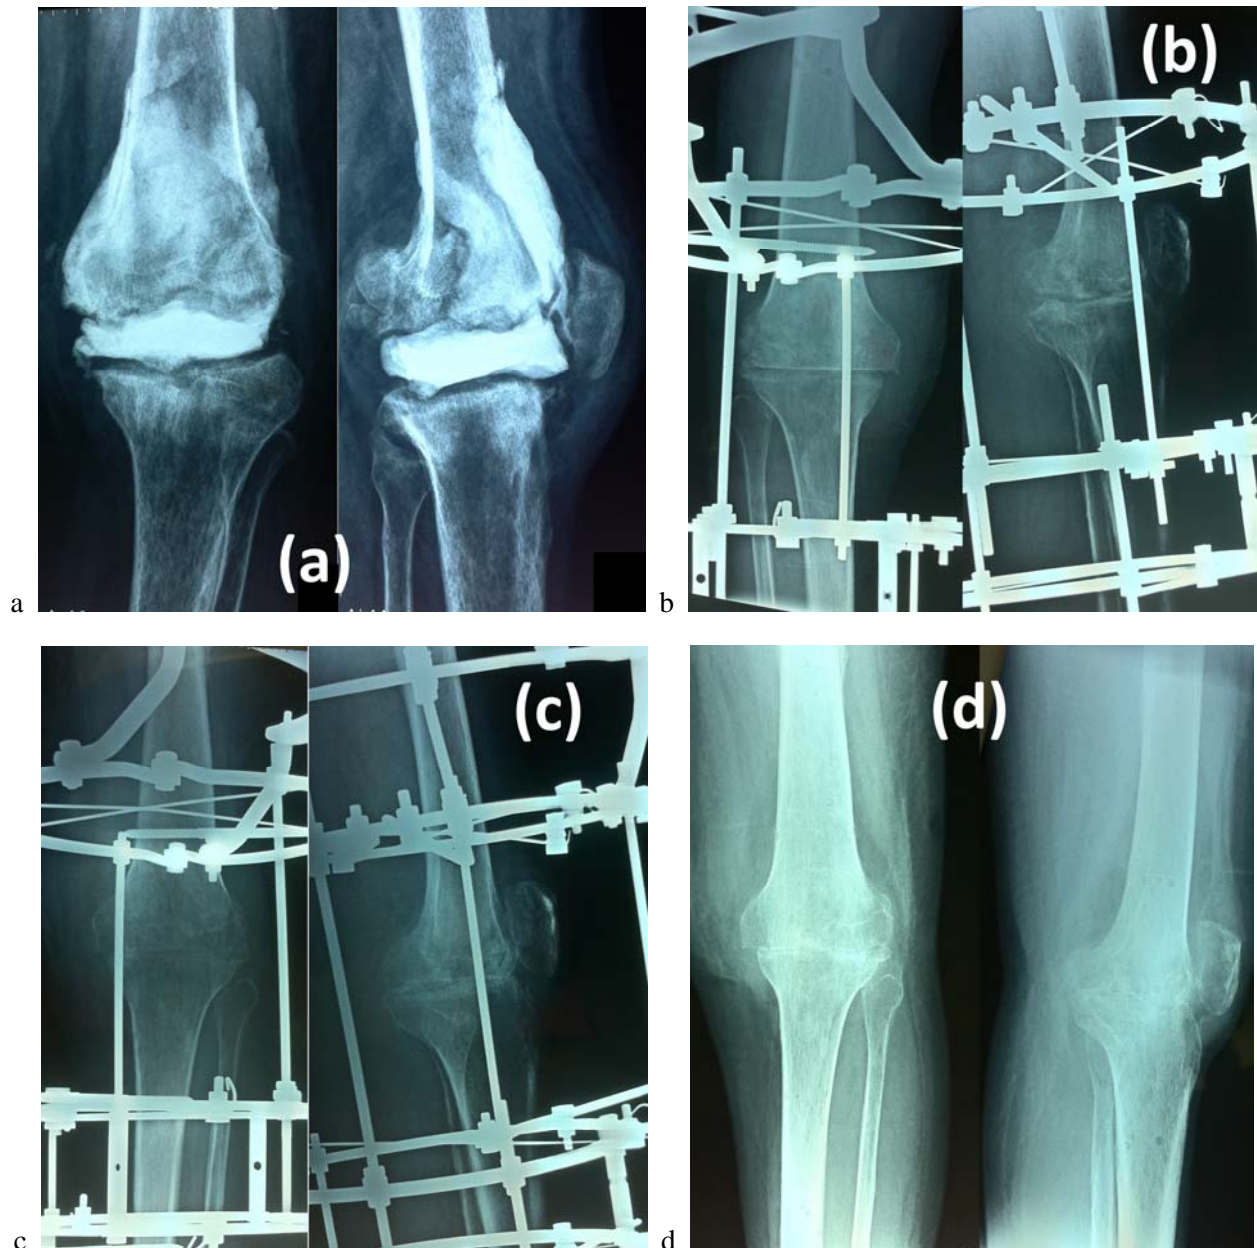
(a) Preoperative radiographs of a case of septic knee arthritis with failed previous debridement and antibiotic bone cement application. (b) First postoperative radiographs. (c) With progression of fusion. (d) After frame removal with sound fusion.
